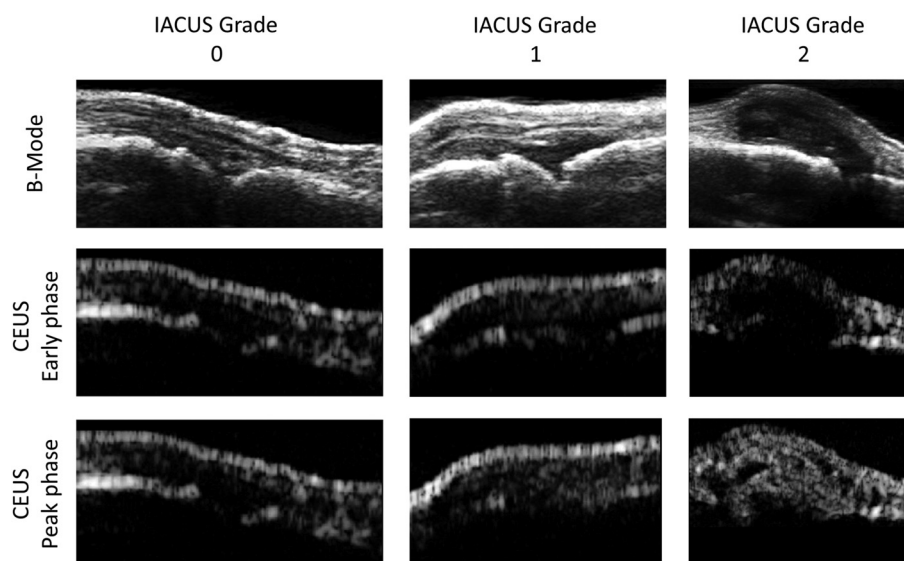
Contrast-enhanced ultrasound (CEUS) data of rheumatoid arthritis (RA) subjects. The B-mode ultrasound image used as anatomical reference is shown (top panel), together with a CEUS image from an early (middle panel) and late (bottom panel) perfusion phase. Each column represents an RA patient with a different grading (from 0 to 2, left to right).
